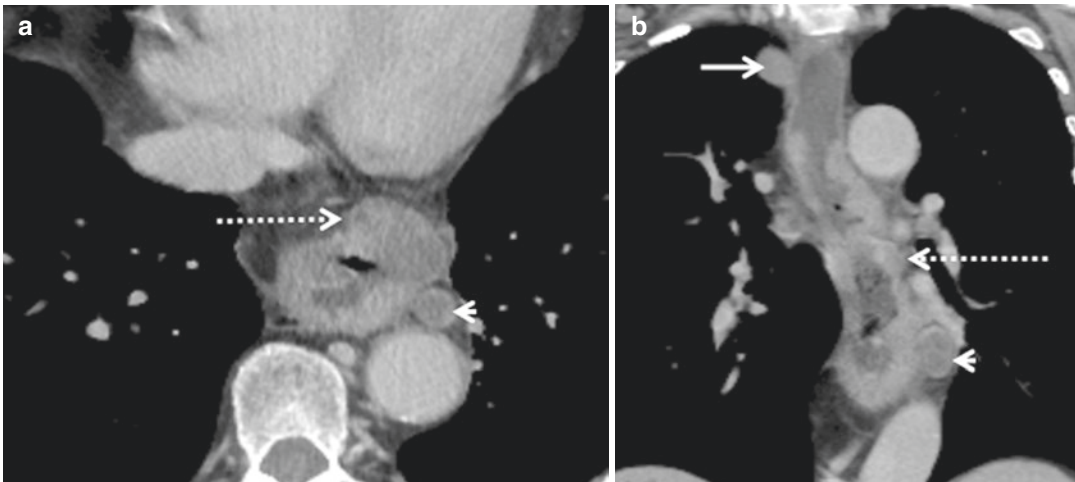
(a) Axial and (b) coronal CT images showing a T3 tumor with tumor extending beyond the esophageal wall into the periesophageal tissues (*dashed arrows*). There is an involved (>10 mm) periesophageal lymph
